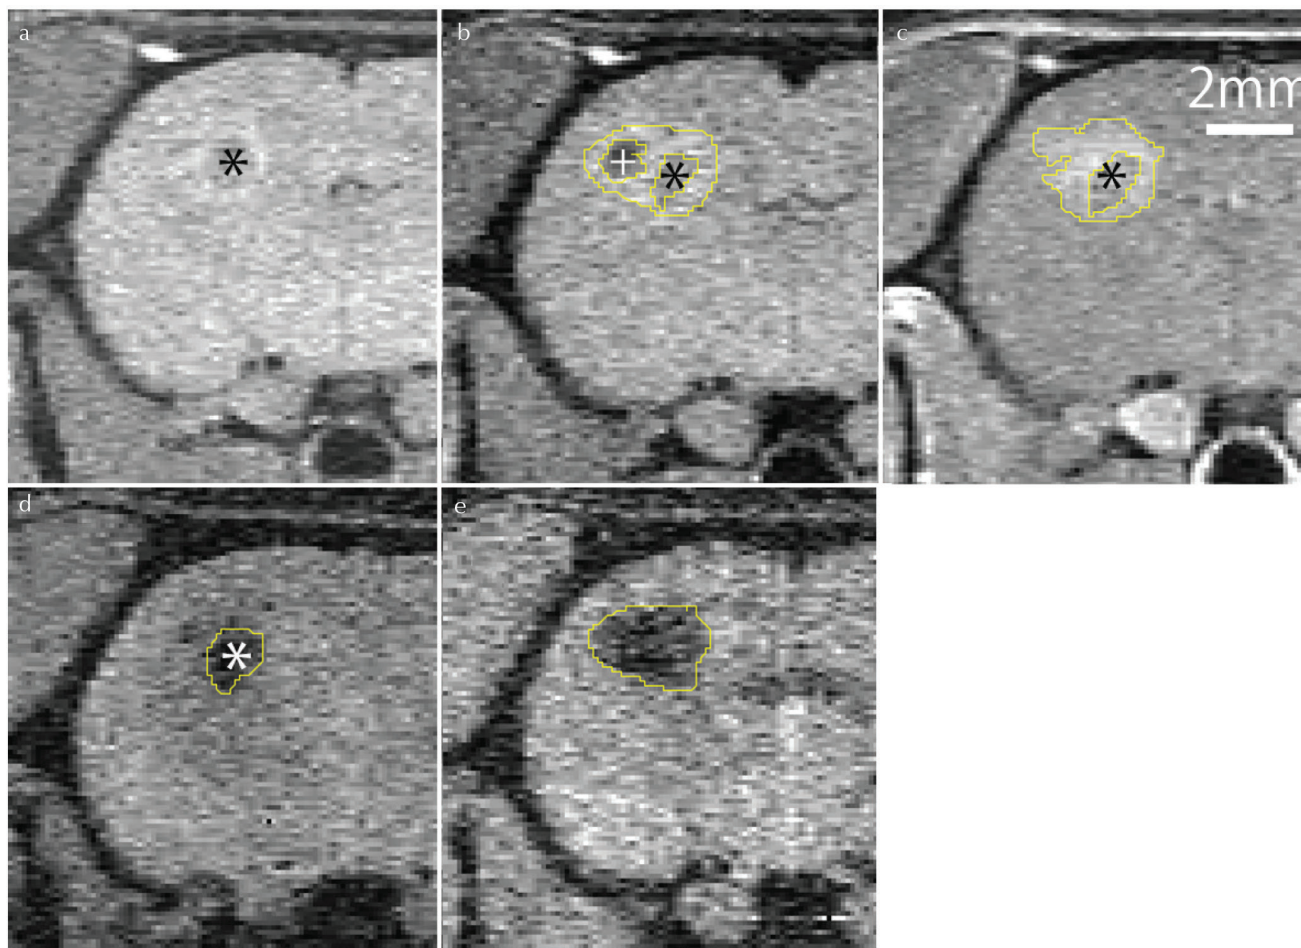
ROI measurement in early-phase USPIO-enhanced and Gd-enhanced MR images of an ENU-induced tumor. SE T_1 WIs obtained (a) pre-contrast and (b) 3 h following administration of USPIO-CA. (c) Gd-enhanced image. Gradient-recalled-echo images obtained (d) pre-contrast and (e) 3 h following administration of USPIO-CA. Hypo-intense intra-tumoral pre-existent hemorrhage (asterisks in a–d) and enhancement areas were manually segmented (yellow ROIs in b–e). Hypo-intense enhancement is demonstrated on USPIO-enhanced spin-echo T_1 WI (+ in b). CA, contrast agent; ENU, N-ethyl-N-nitrosourea; ROI, region of interest; SE, spin-echo; T_1 WI, T_1 -weighted image; USPIO, ultrasmall superparamagnetic iron oxide. (Color version is available online)
